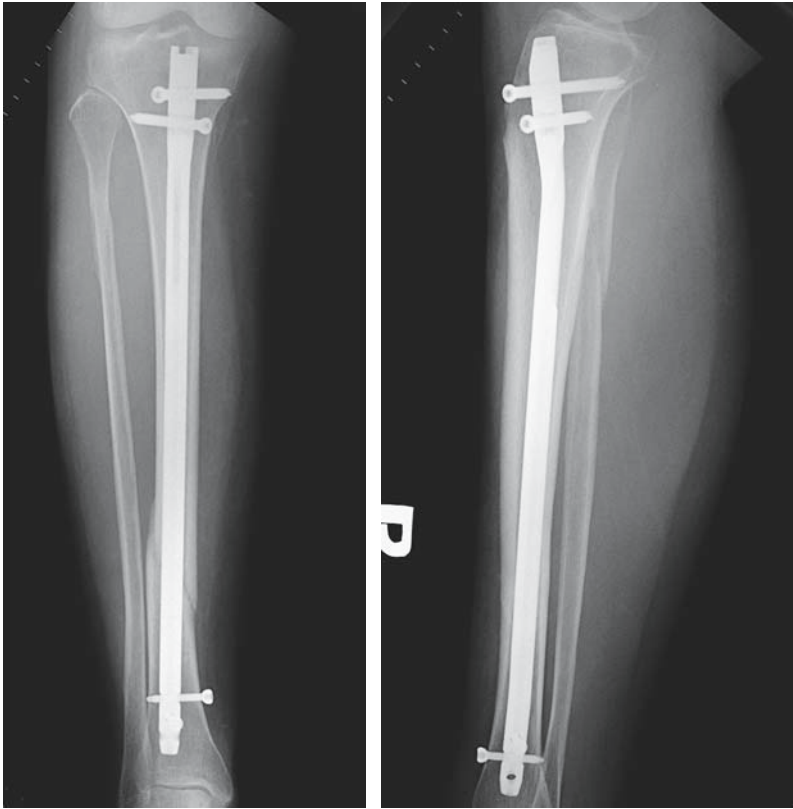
Radiographs of the tibia after healing.
